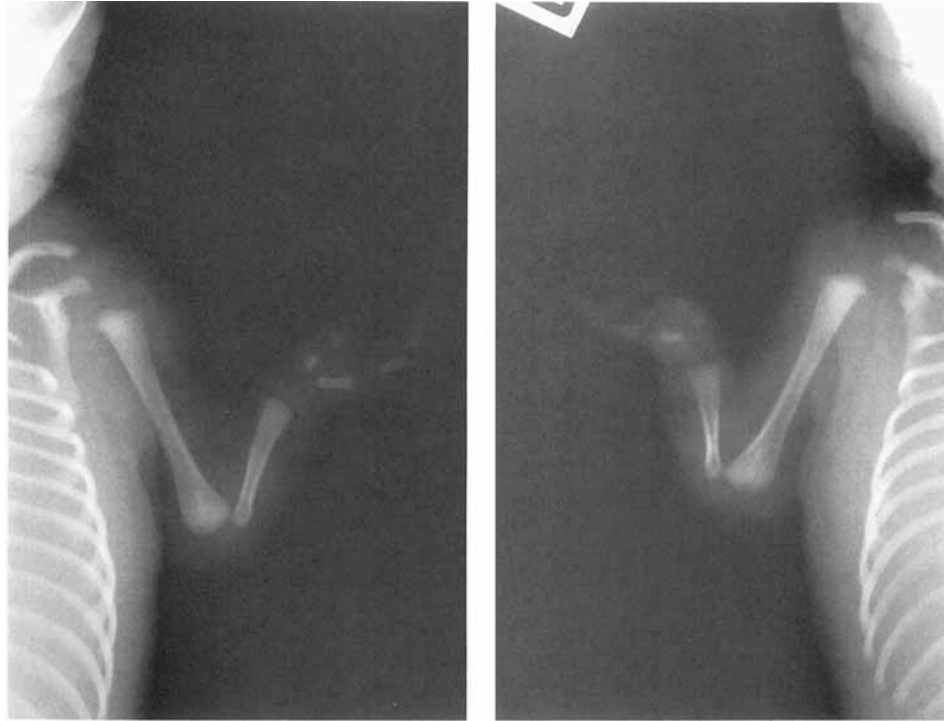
Patient 3. Radiographs showing bilateral ulnar aplasia and radial hypoplasia, oligodactyly with absence of third, fourth, and fifth rays, and presence of 13 ribs.
